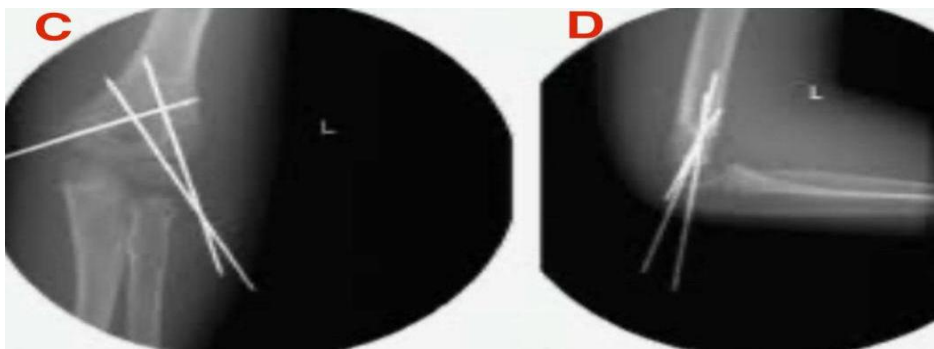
X-ray of intraoperative AP and lateral views showing 2 lateral K-wires with medial crossed K-wire fixation
